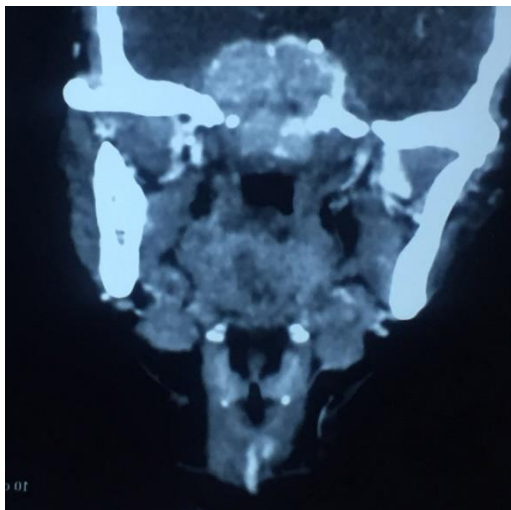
CT Scan of lesion in pituitary fossa, extending into nasopharynx, sphenoid sinus cells
